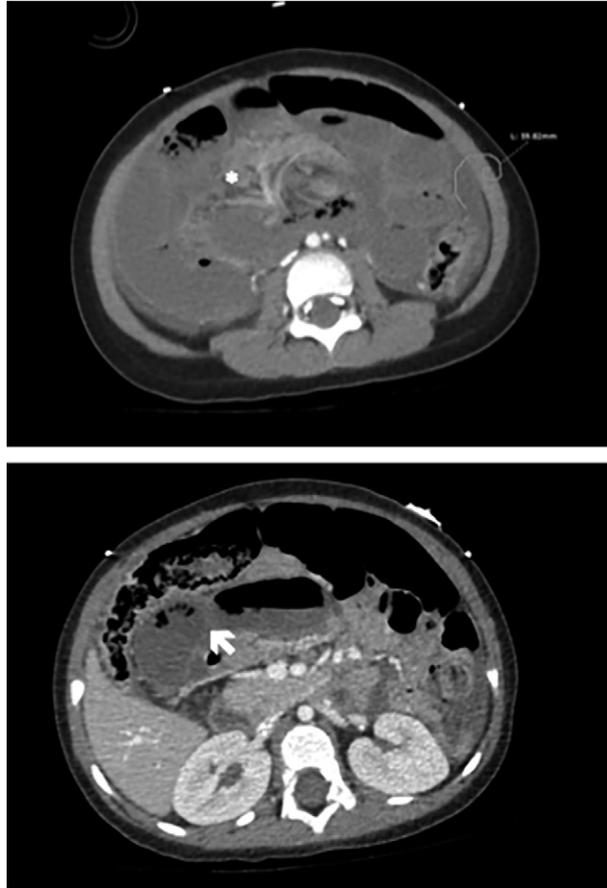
Axial sections of CT study (with contrast) of the abdomen showing the swirling of the mesentery (*) and a fluid-filled loop of bowel with peripheral foci of air concerning for pneumatosis (white arrow).
